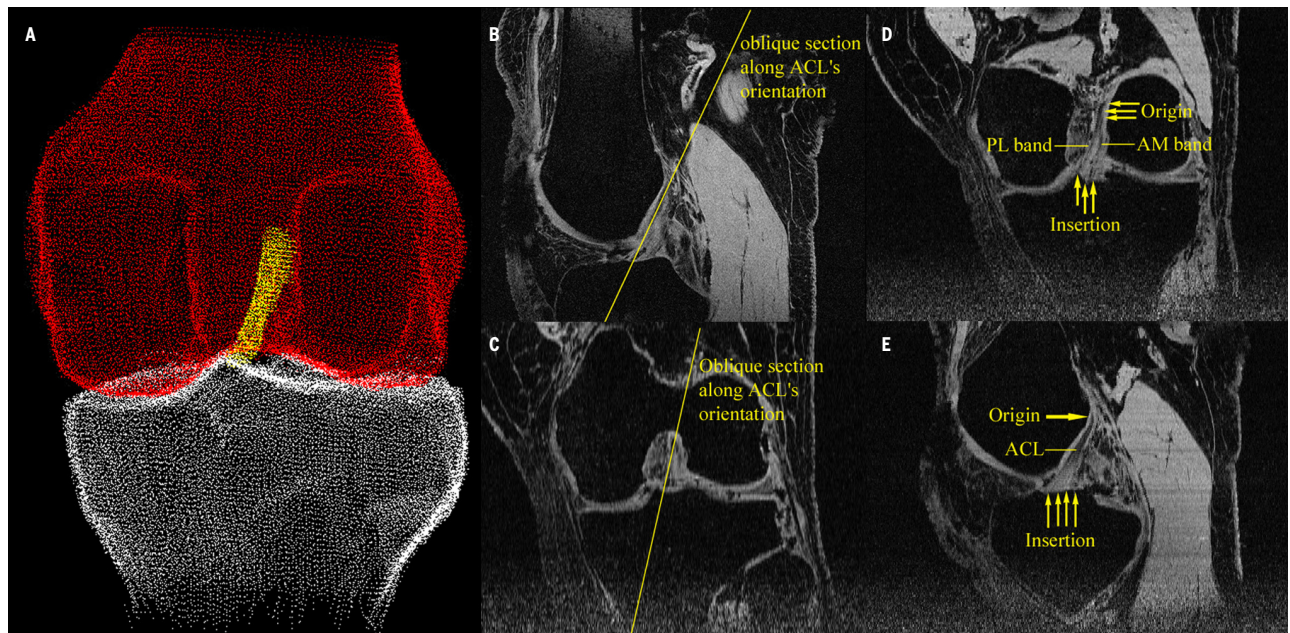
Geometric reconstruction of the knee (A) using MR images on scanned axial, and interpolated oblique coronal (B, D) and oblique sagittal (C, E) planes.
